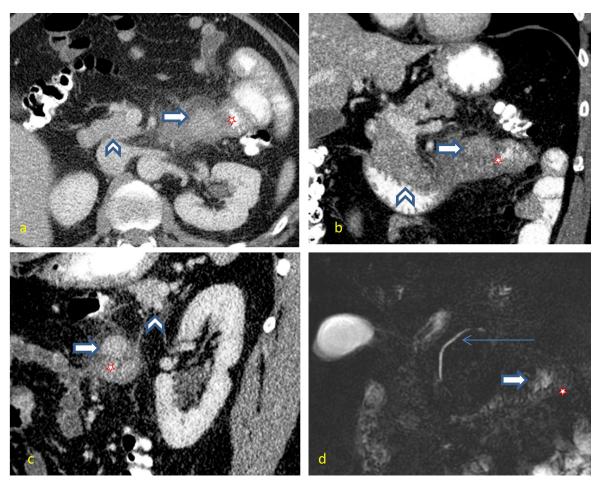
Contrast-enhanced CT in portal venous phase (a-c) shows a jejunal mass (block arrow) with density similar to the normal native pancreatic density (arrowhead). Note the adjacent edematous thick wall duodenum and proximal jejunum. (d) MRCP demonstrates the relation between native pancreas (thin long arrow-main pancreatic duct) and ectopic pancreas near the duodenojejunal flexure. No accessory duct was demonstrated in this case. Jejunum is marked as 3.
